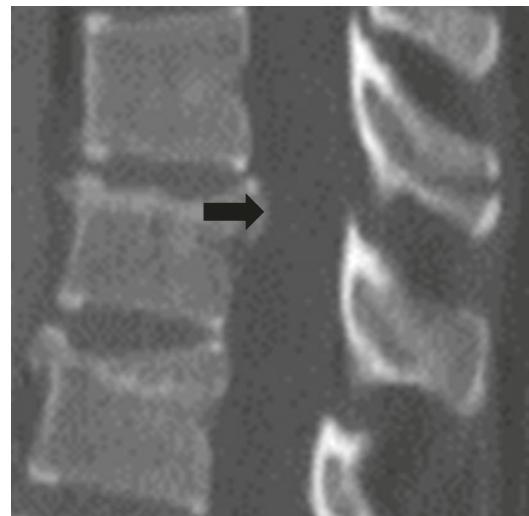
Twenty four-year-old woman presenting after fall from 15 ft, with back pain. Detail of sagittal CT image in bone window shows compression fracture deformities of T12 and L1, with posterior retropulsion of the T12 fracture fragment (arrow). MRI spine was recommended for evaluation of possible spinal cord injury
